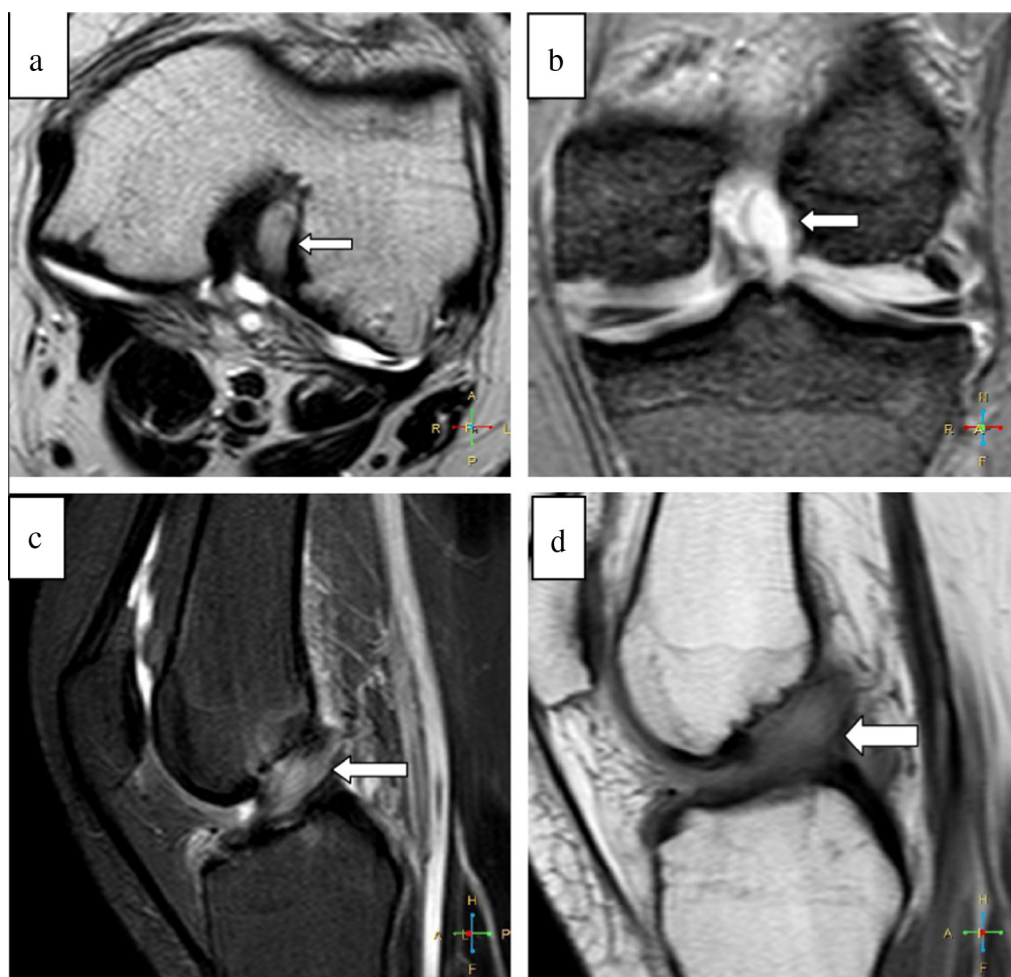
(a) Coronal FSE T2 fat suppression, (b) sagittal FSE PD, (c) sagittal FSE T2 and (d) sagittal STIR MRI of the right knee. The ACL presented fuzzy outline with areas of intermediate signal intensity in all pulse sequences within its substance, yet its fibers are seen stretched. Findings are those of ACL contusion.
